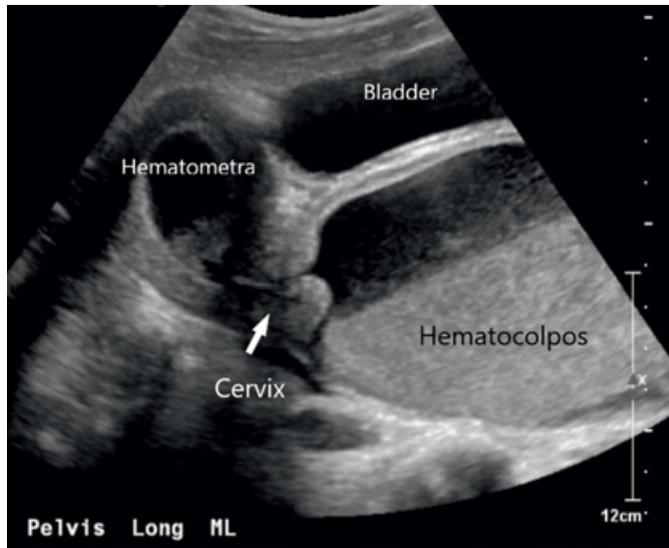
Ultrasound showing hematometra and hematocolpos.
